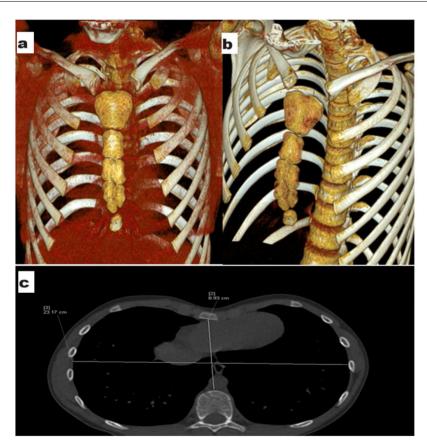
Honeycomb sternum on CT imaging (a, b) and Haller Index measurement (c).
